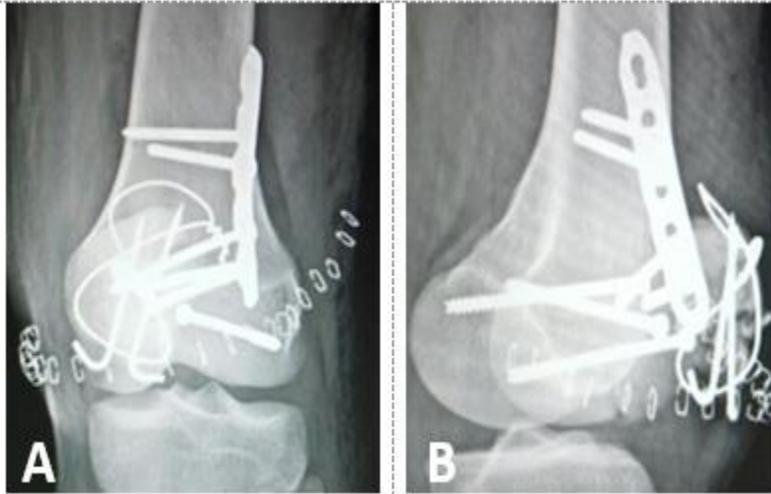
Post-op Xray Left AP and Lateral View Distal Femur with patella
